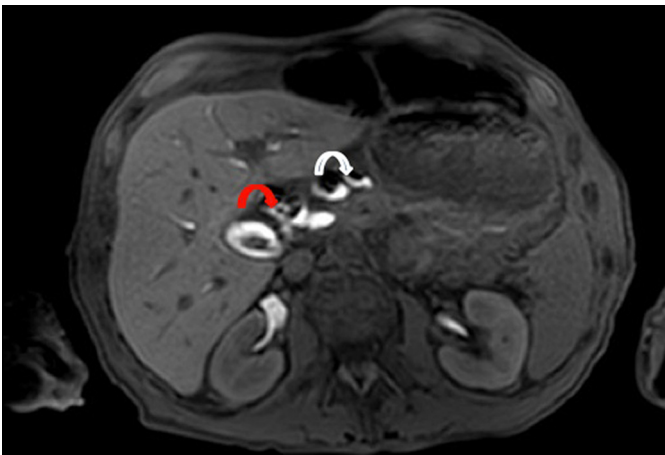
Magnetic resonance imaging showing bile duct perforation (red arrow) and bile collecting in the lesser sac (white arrow).
